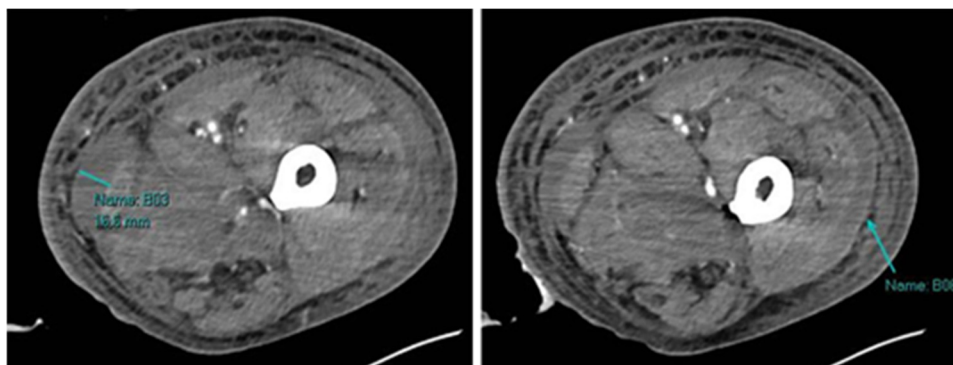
CT image of fluid surrounding the medial (left) and lateral (right) muscular fascia.
